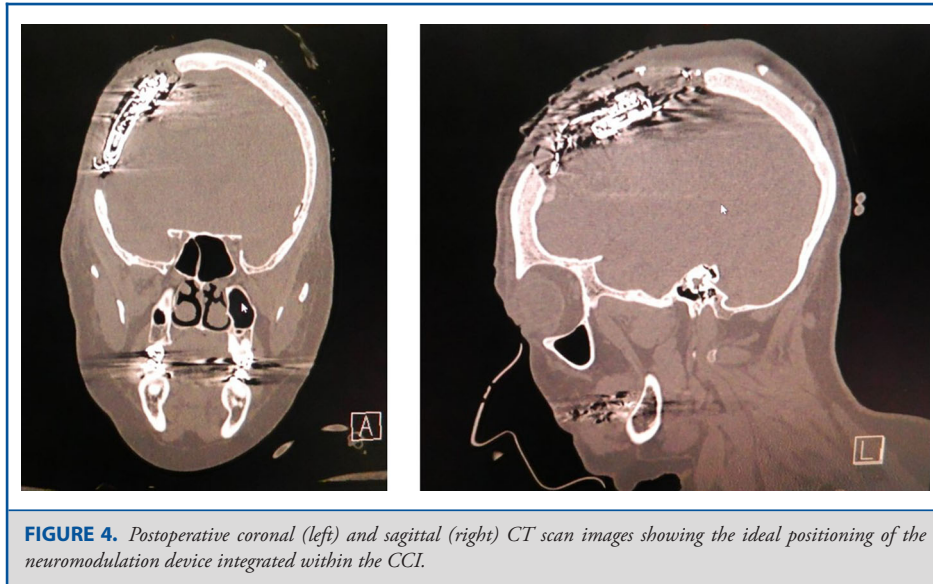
Postoperative coronal (left) and sagittal (right) CT scan images showing the ideal positioning of the neuromodulation device integrated within the CCI.
